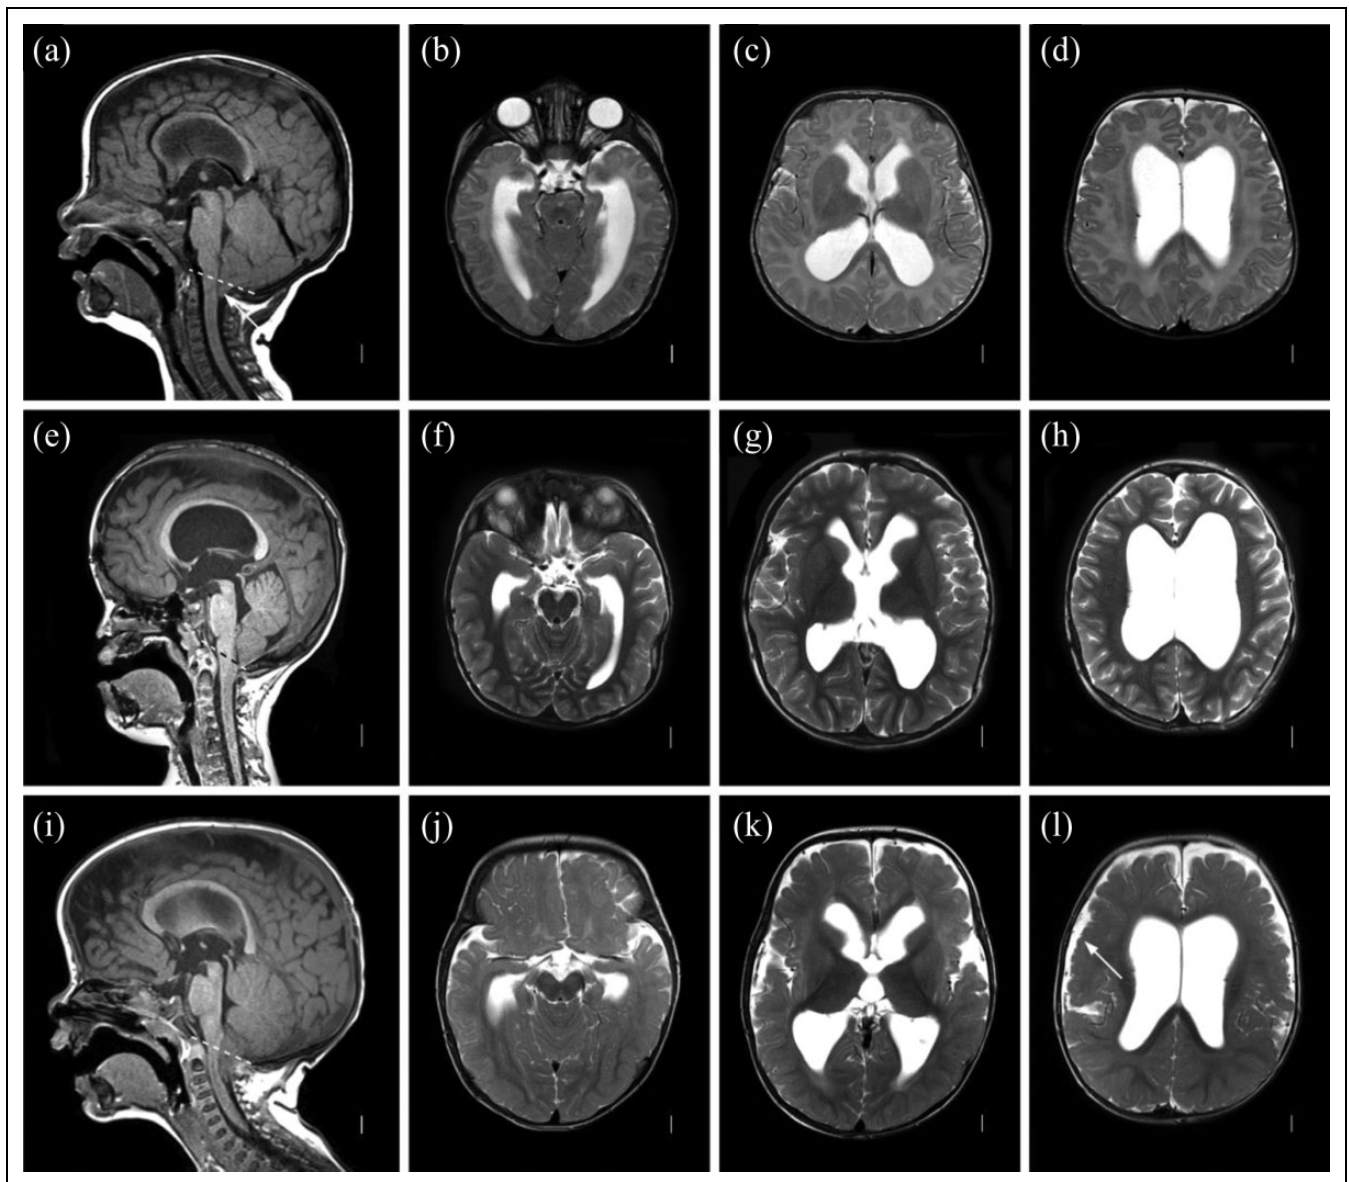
Posterior fossa crowding. (A-D) Chiari I malformation. Axial T1 MRI image (A) showing open aqueduct and relatively large-appearing cerebellum, with herniation of tonsils below foramen magnum (dashed line). Axial T2 images (B-D) showing moderate dilation of lateral ventricles. (E-H) Pfeiffer syndrome with multisuture synostosis. Sagittal T2 images (E) showing midface retrusion, widely patent aqueduct, and small, crowded posterior fossa with tonsillar herniation below the foramen magnum (dashed line) in patient with a confirmed *FGFR2* mutation. Axial T2 images (F-H) showing moderate ventricular dilation. (I-L) Megalencephaly, polydactyly, polymicrogyria, and hydrocephalus syndrome. Sagittal T1 image (I) showing widely patent aqueduct with tonsillar herniation through foramen magnum (dashed line). Axial T2 image showing moderate ventricular dilation (J-L) and extensive bilateral perisylvian polymicrogyria (L, arrow).
